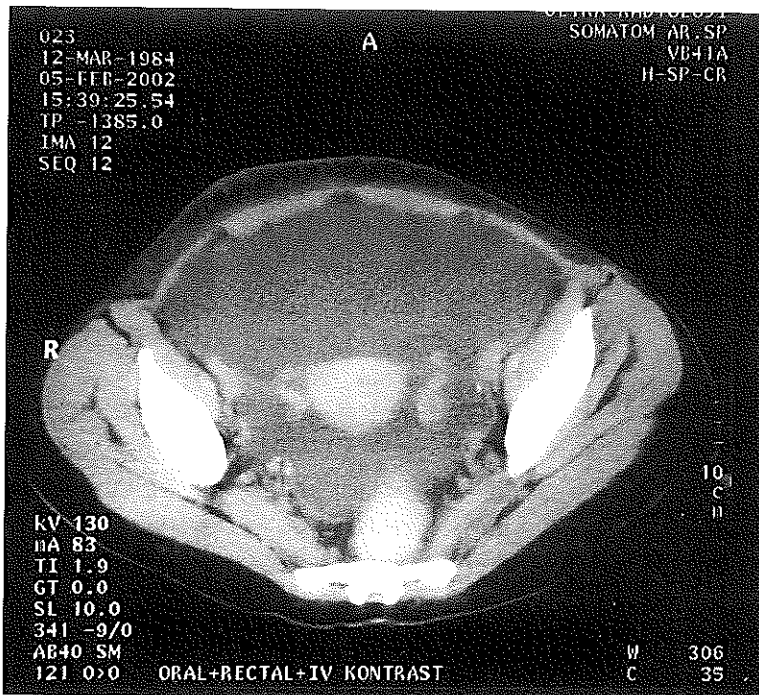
Abdominal computed tomography revealed massive ascites.
